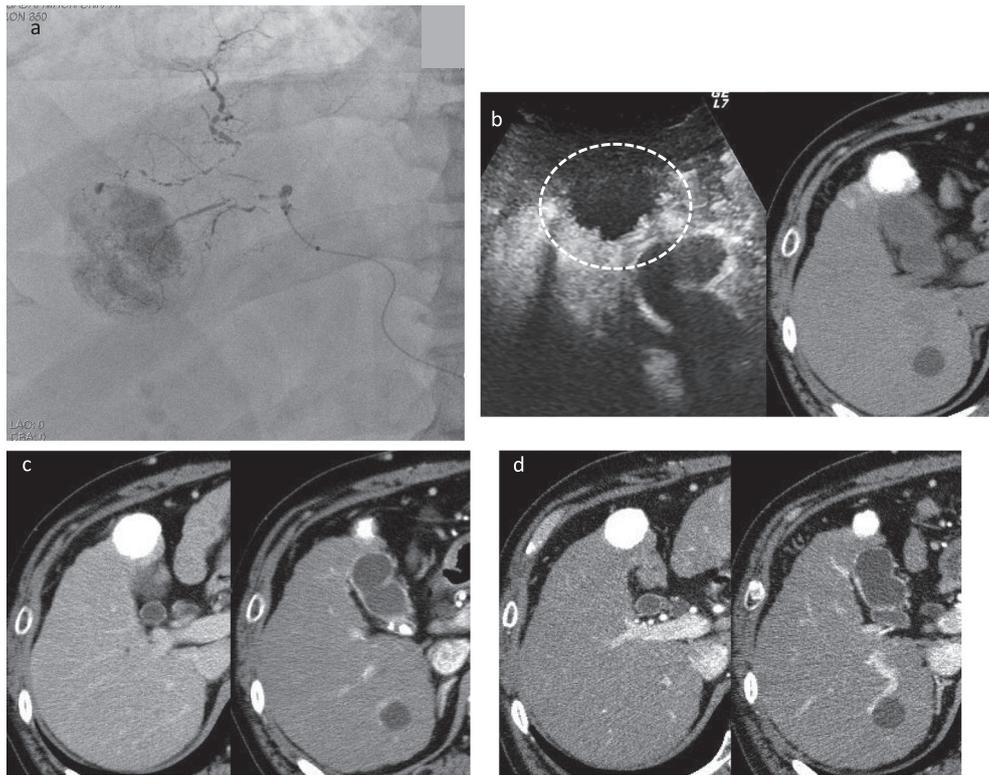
A case of hepatocellular carcinoma (the patient in Fig. 4) treated using B-TACE for local recurrence. B-TACE was performed slightly on the central side compared with the previous treatment. (a) Angiography of the right hepatic artery. (b) Contrast-enhanced ultrasonography on the day after treatment and a non-contrast CT image on the day after treatment showing lipiodol accumulation corresponding to a TE4 efficacy evaluation. (c) Arterial dominant phase in contrast-enhanced CT 1 month after treatment, showing no local recurrence. (d) Arterial dominant phase in contrast-enhanced CT 4 months after treatment, also showing no local recurrence. B-TACE, balloon-occluded transarterial chemoembolization; CT, computed tomography; C-TACE, transcatheter arterial chemoembolization using a conventional microcatheter.
